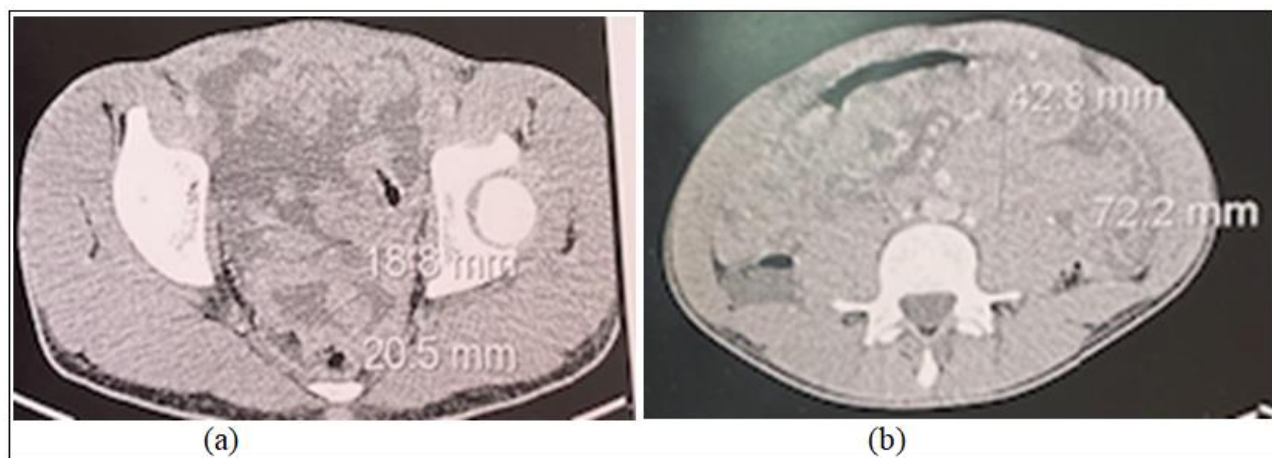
Abdominal CT image showing a circumferential and irregular thickening of the sigmoid colon measuring 11 and 15 mm thick, enhanced by the contrast, associated with an ascites of great abundance occupying the entire abdominopelvic cavity with infiltration of the omentum and mesenteric fat, peritoneal nodule measuring at pelvic level 18x20 mm for the largest. (a) Lower mesenteric mass of 42x72 mm, (b) moderately enhanced by the contrast in close contact with free vessels which may suggest a tumor origin in the first place
